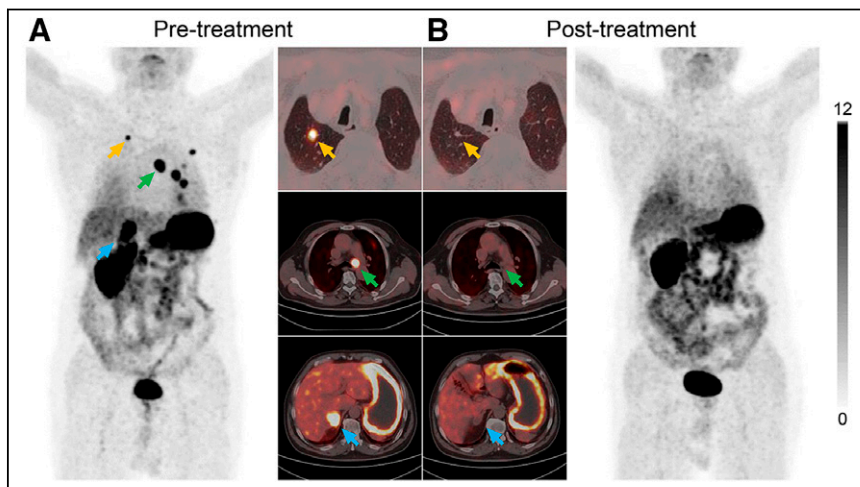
Images of patient 12 (73-y-old man), who underwent left nephrectomy with pathologically confirmed ccRCC and suspected tumor metastases on follow-up. (A) Images from pretreatment ^{68}Ga]Ga-NYM046 PET/CT demonstrate mediastinal lymph node metastases (green arrows), lung metastases (yellow arrows), and right adrenal metastases (blue arrows). (B) After 2 treatment cycles, all metastases were negative for uptake.
